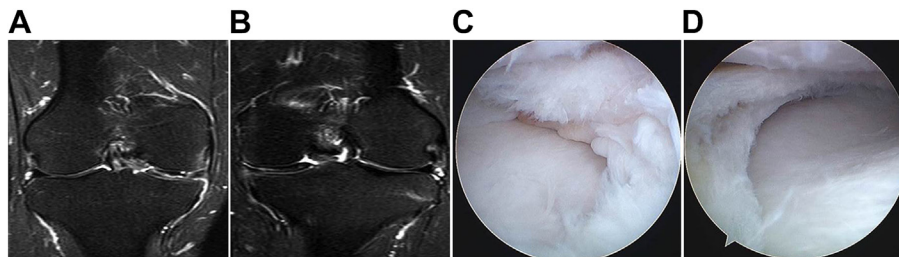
MRI and arthroscopic images of a 21-year-old male (patient 2) who presented with pain and swelling in both knees. (a) Coronal T2-weighted image of the right knee showing a complex tear of the medial meniscus with the medial tibial plateau being completely covered. (b) Coronal T2-weighted image of the left knee showing complete discoid medial meniscus with a horizontal cleavage tear. (c) In probing of the peripheral side of the discoid medial meniscus of the right knee, a degenerative longitudinal tear running from the body portion to the posterior horn was observed, and the margin of the torn meniscus showed severe fatty degeneration. A subtotal meniscectomy was performed in the right knee. (d) Arthroscopic partial meniscectomy involving the torn meniscus was performed in the left knee. For the inner horizontal cleavage tear, the inferior surface was also resected.
